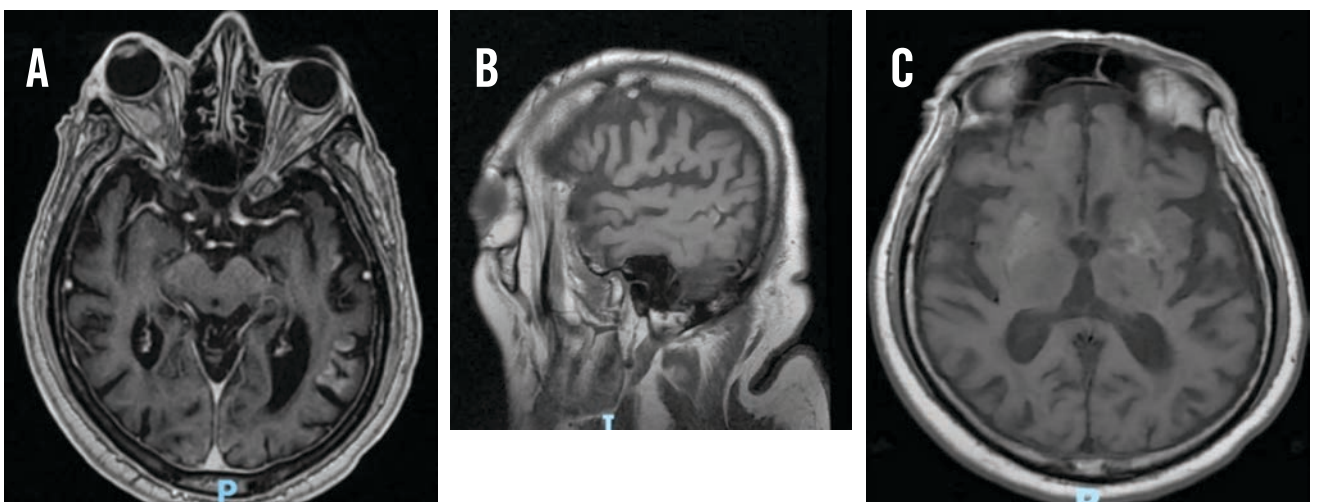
Gyriform increased FLAIR signal intensity indicating edema in the left temporal lobe, parietal lobes and bilateral occipital lobes associated with enhancement. A - Compared to the prior exam edema/FLAIR signal has decreased enhancement is also less conspicuous; B - There is cortical laminar necrosis in the left posterior temporal lobe; C - Increased T1 signal intensity in bilateral lentiform nuclei, more prominent compared to the prior exam
